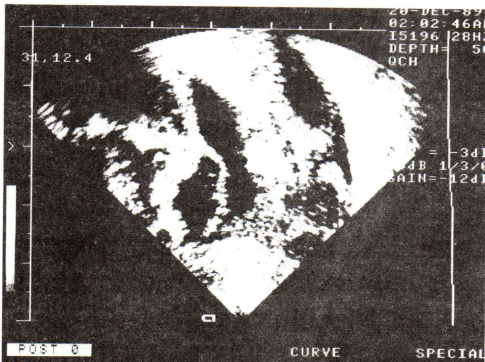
Transvaginal sonography shows cross-sectional scan of a lumbar spina bifida which could not be seen by transabdominal scan at 6 weeks gestation.
